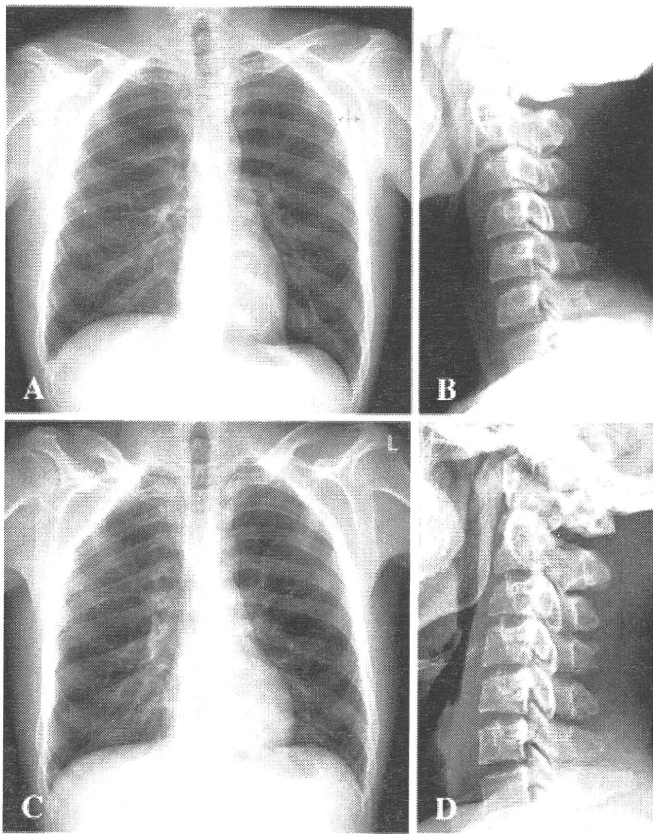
Radiographies of the chest and cervical spine of Patients 1 (A, B) and 2 (C, D) showed mild thoracic deformity (A, C), and mild hypoplasia of vertebral body and spinous process (B, D).
